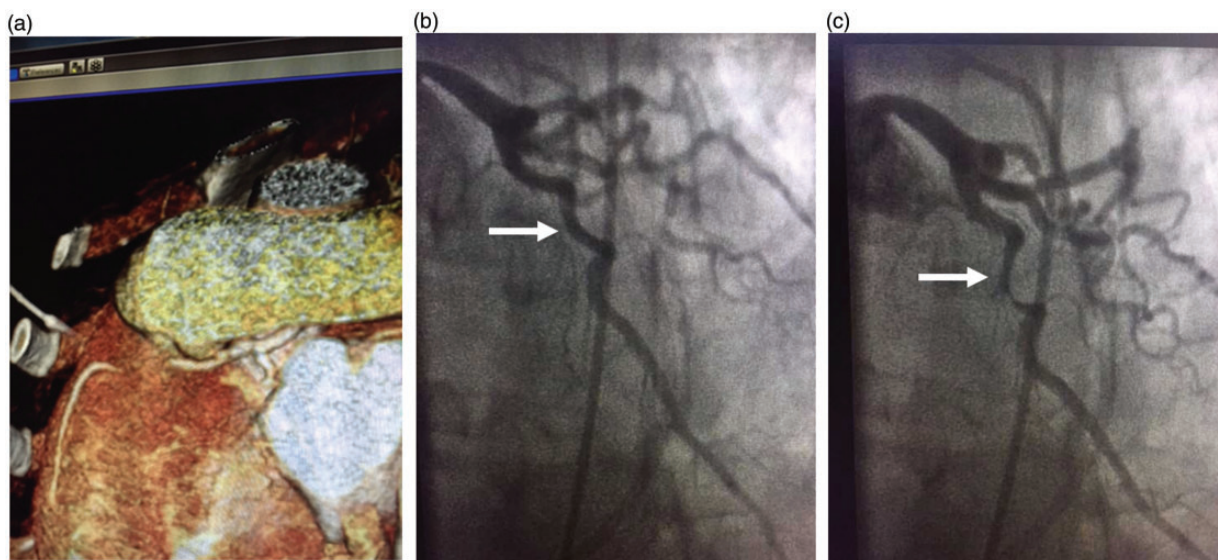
(a) CT angiogram showing the epicardial left anterior descending coronary artery (LAD) being bridged by the myocardium over a length of 13 mm. (b, c) Angiography (still frame) in end-diastole (b) and systole (c) showing a dynamic narrowing of the mid LAD (arrows).
